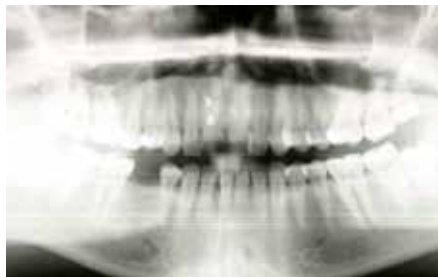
Radiograph showing endodontic infection of tooth 11.
